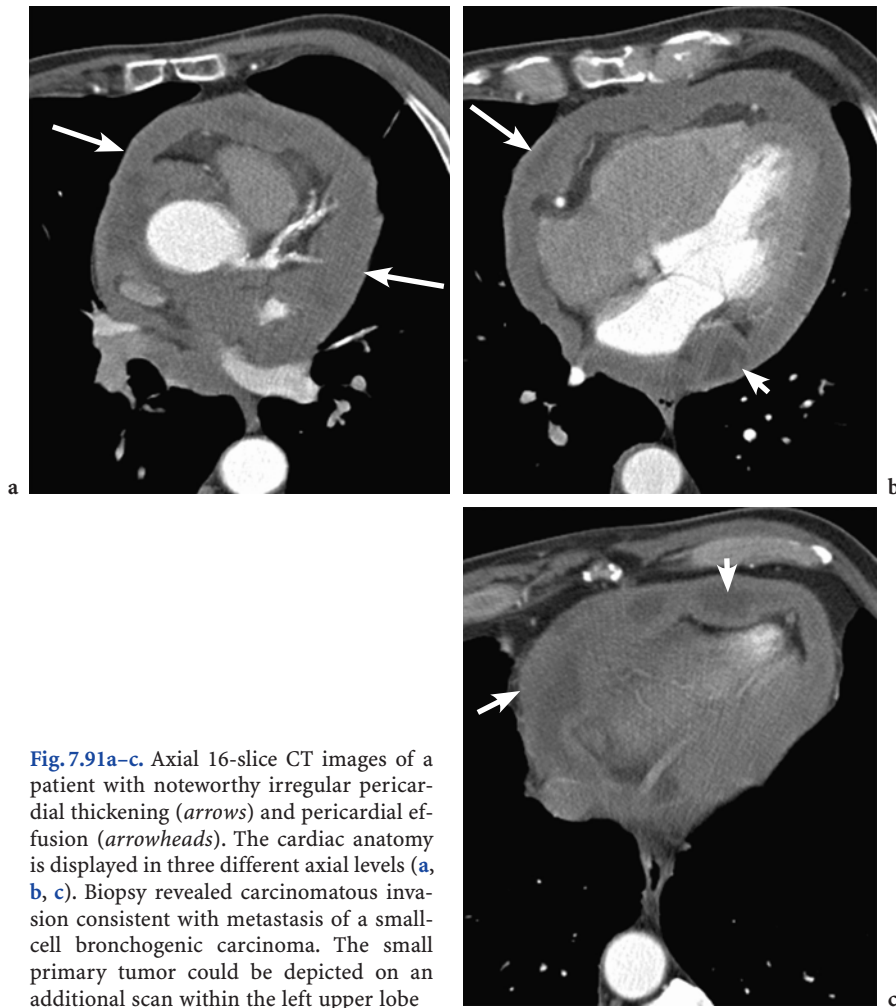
Axial 16-slice CT images of a patient with noteworthy irregular pericardial thickening (*arrows*) and pericardial effusion (*arrowheads*). The cardiac anatomy is displayed in three different axial levels (*a*, *b*, *c*). Biopsy revealed carcinomatous invasion consistent with metastasis of a small-cell bronchogenic carcinoma. The small primary tumor could be depicted on an additional scan within the left upper lobe
